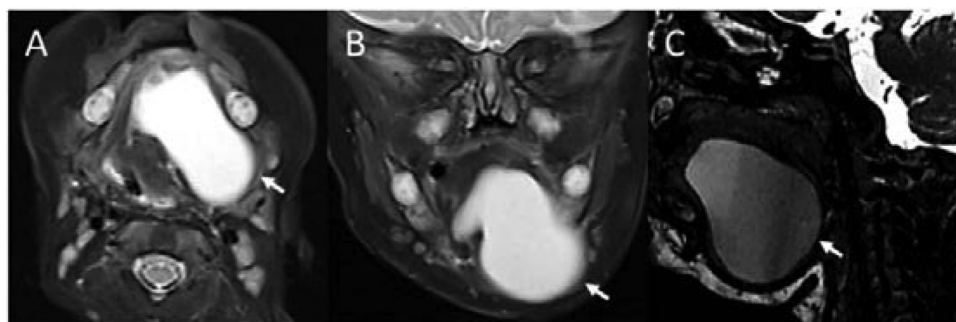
Axial T2-weighted (A), coronal T2-weighted (B), and sagittal fat-suppressed T2-weighted (C) MR images of a child with a large plunging ranula. The axial image (A) demonstrates a large thin-walled cystic structure in the floor of the mouth. The coronal image (B) shows posterior extension of the cystic structure from the sublingual space into the left submandibular space. The maximal volume of the plunging ranula is localized in the submandibular space. Note the layering debris due to protein-rich material in the cyst on the sagittal image (C).
